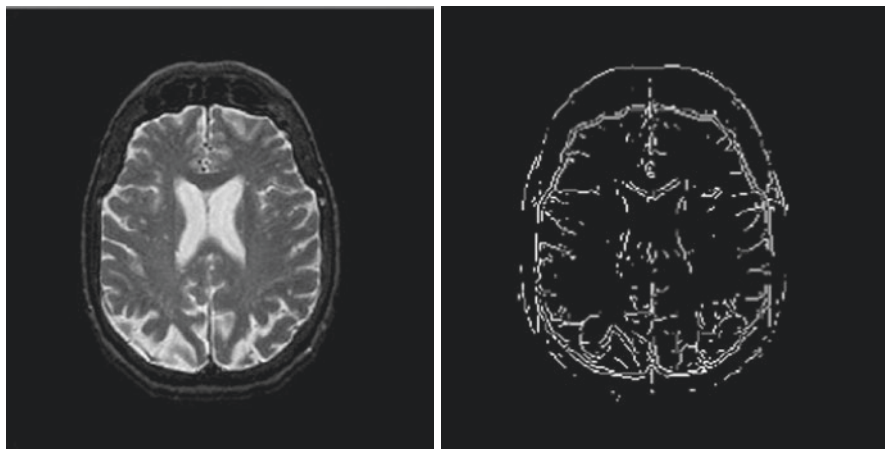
Normal MRI (*left*) and its Sobel-filtered image in Hilbert domain (*right*)
